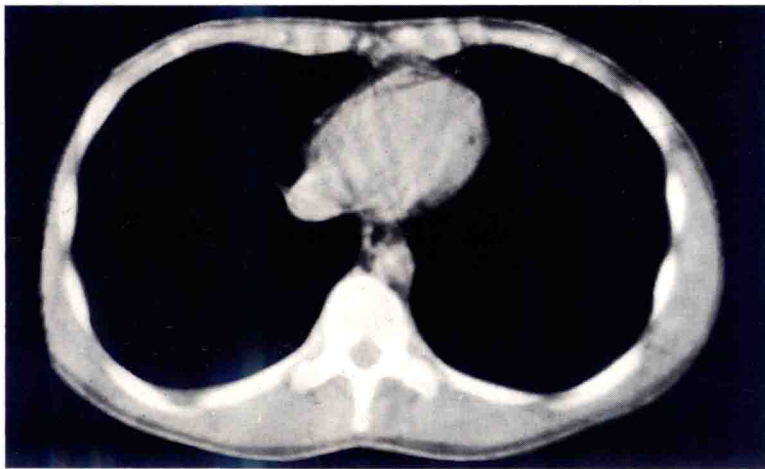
Transverse computerized tomographic (CT) scan of the thorax at the level of T4.
